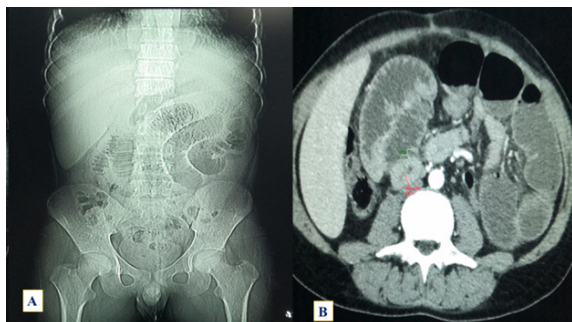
A) Abdominal radiography showing a dilated small bowel. B) CT scan: axial post IV contrasted abdominal study; a picture of the enhanced jejunal wall, with focal wall thickening and signs of pseudo intestinal obstruction.
